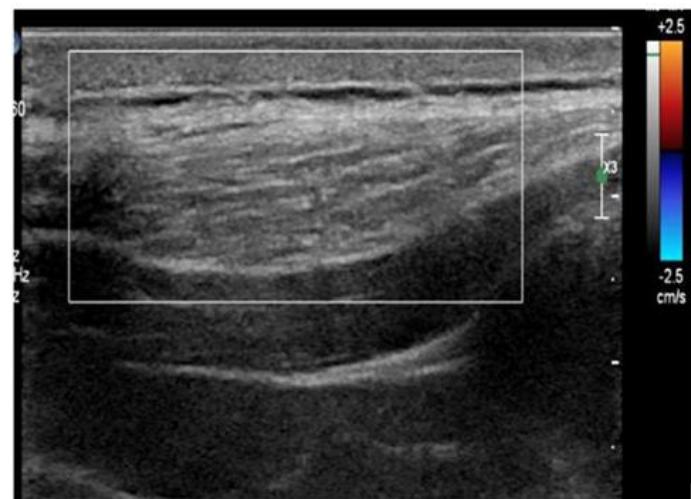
(A, B, C, D): Grey scale image showing a well-defined, lobulated heterogeneously hypoechoic lesion in the left anterior abdominal wall in the subcutaneous plane. There are no calcifications or cystic changes. The lesion shows peripheral vascularity on Color Doppler. Tsukuba score (TES Score) –4 (Blue). The Strain Ratio is 2.87. HPE: Tumor cells are large, ovoid with increased N:C ratio, round to oval nucleus exhibiting moderate nuclear atypia, dense coarse granular chromatin, one to two nucleoli and moderate dense eosinophilic cytoplasm. Positive for malignancy, features suggestive of Metastatic poorly differentiated carcinomatous deposits, possibly squamous-Anterior abdominal wall deposit. In a primary case of carcinoma cervix, the above features are suggestive of ABDOMINAL WALL METASTATIC DEPOSIT (Malignant Lesion).
